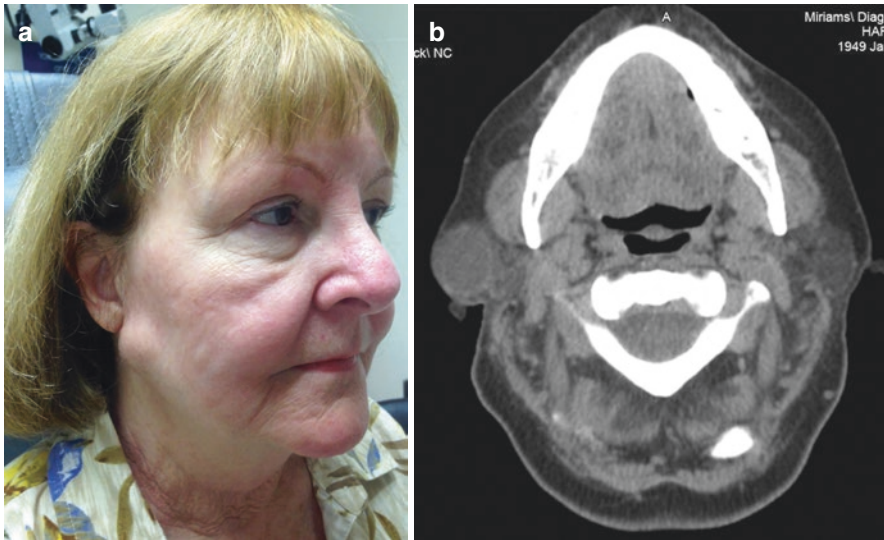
(a) Parotid sialoceles formation after laser lithotripsy of a proximal ductal stone. (b) Axial CT scan at the level of the parotid gland displaying a cystic
